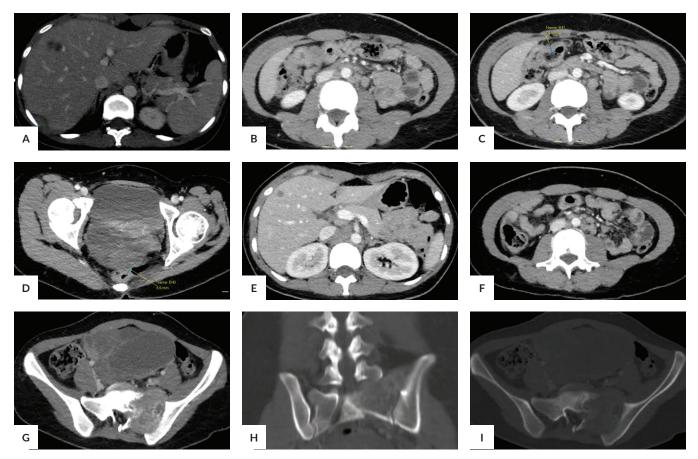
Contrast-enhanced CT. Other findings showed (A) hepatic nodules; (B-D) segmental colonic wall thickening; (E-F) abdominal lymphadenopathy; (G-I) ill-defined enhancing lytic sacral bone lesions.
